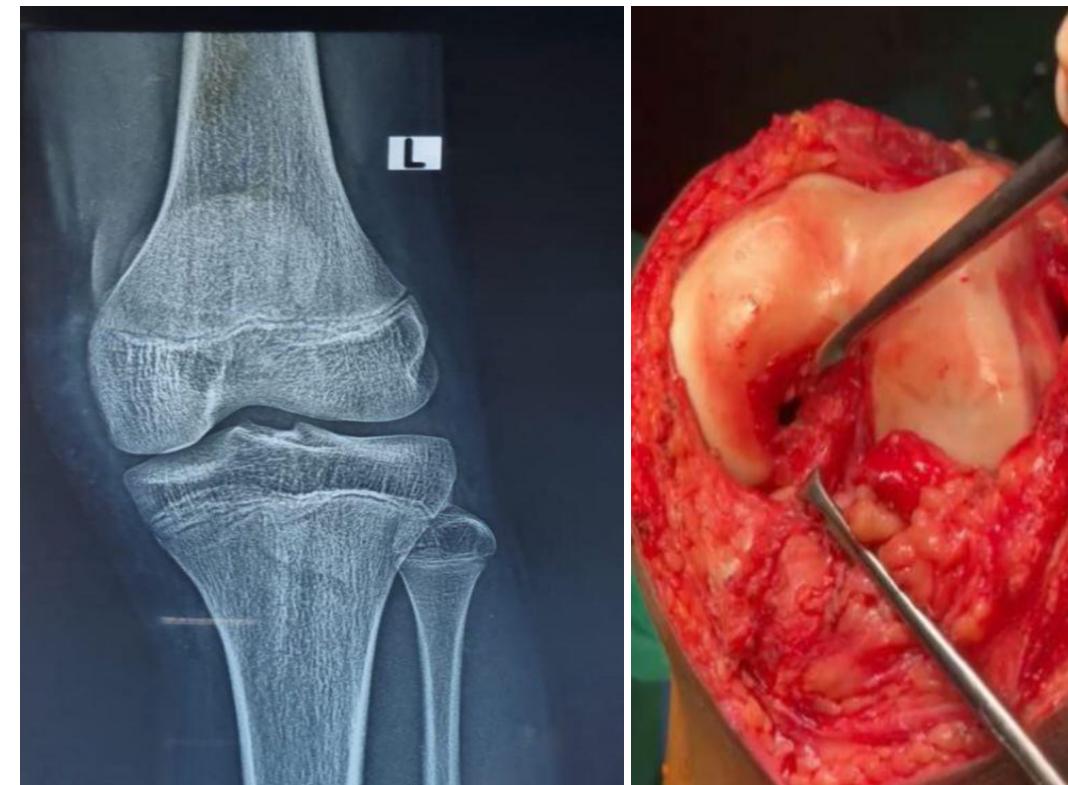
Preoperative plain radiograph (AP view) of the left knee demonstrating a well-defined eccentric lytic lesion in the epiphysis of the proximal tibia with a thin sclerotic rim.
